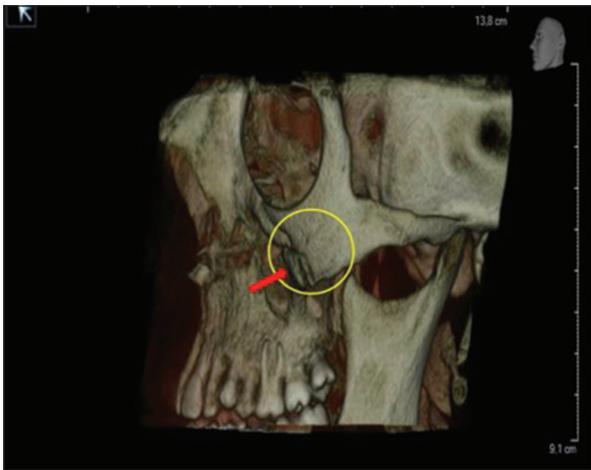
Postoperative three-dimensional cone-beam computed tomography image
